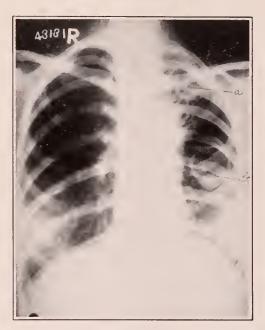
Case I. Roentgenogram Nov. 30, 1929, showing two cavities on the left side, one at apex (a), and the other 4 cm. in diameter just below hilus level (b).
